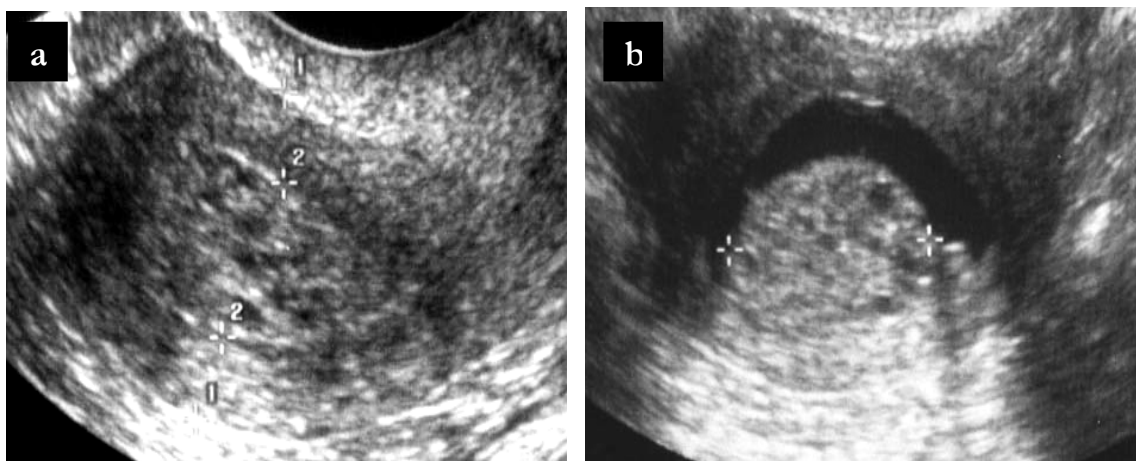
(a) polyp at conventional ultrasound; (b) polyp at hydrosonegography
